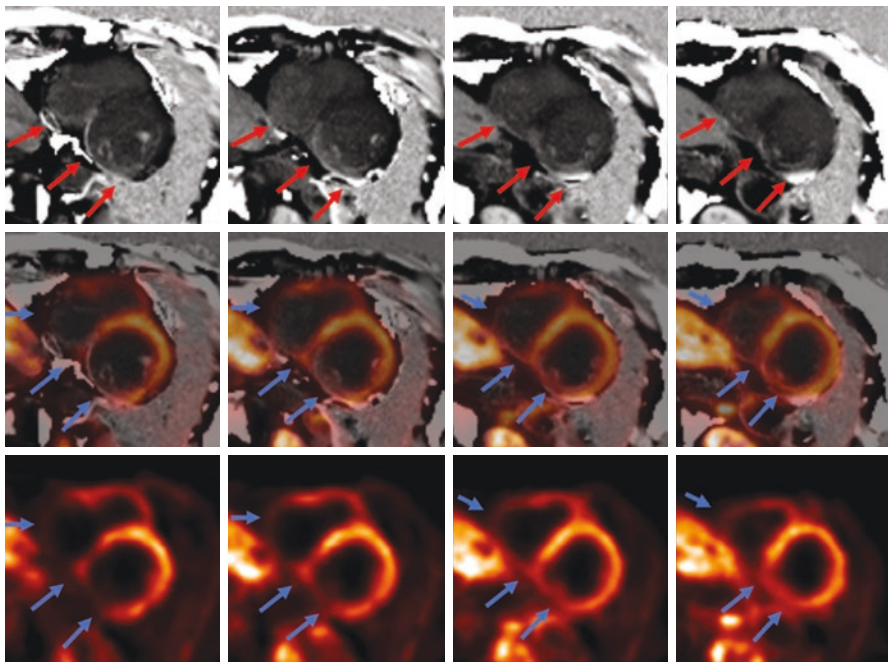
Case example of a patient with a history myocardial infarction of the inferior wall who underwent F-18 flubromenguane (^{18}F -LMI1195) PET/MRI. Red arrows depict late gadolinium enhancement in MRI as a sign of scarring (upper row), while blue arrows point at decreased tracer uptake in PET indicating denervated areas (bottom row). Overlay of PET and MRI is demonstrated in the middle row. Note that scarring and denervation can also be seen in the inferior part of the right ventricle. (Reprinted with permission from Rischpler C et al. “Cardiac PET/MRI: Current Clinical Status and Future Perspectives.”, *Semin Nucl Med.* 2020 May;50(3):260–269)
